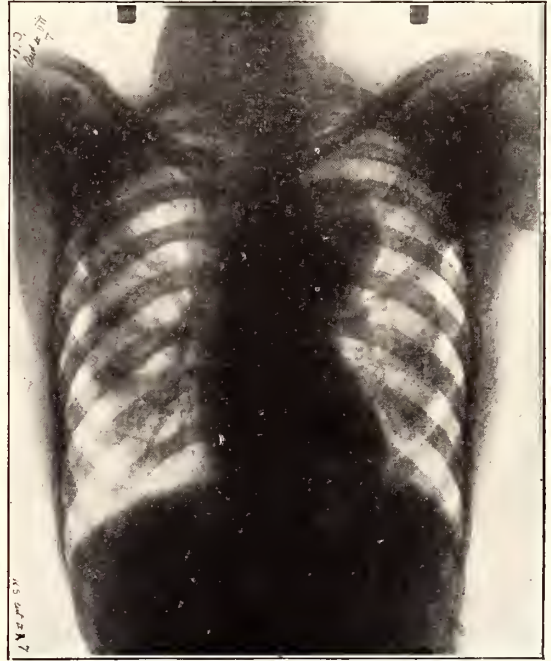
Radiograph of aneurysm described in report of case No. 5.
